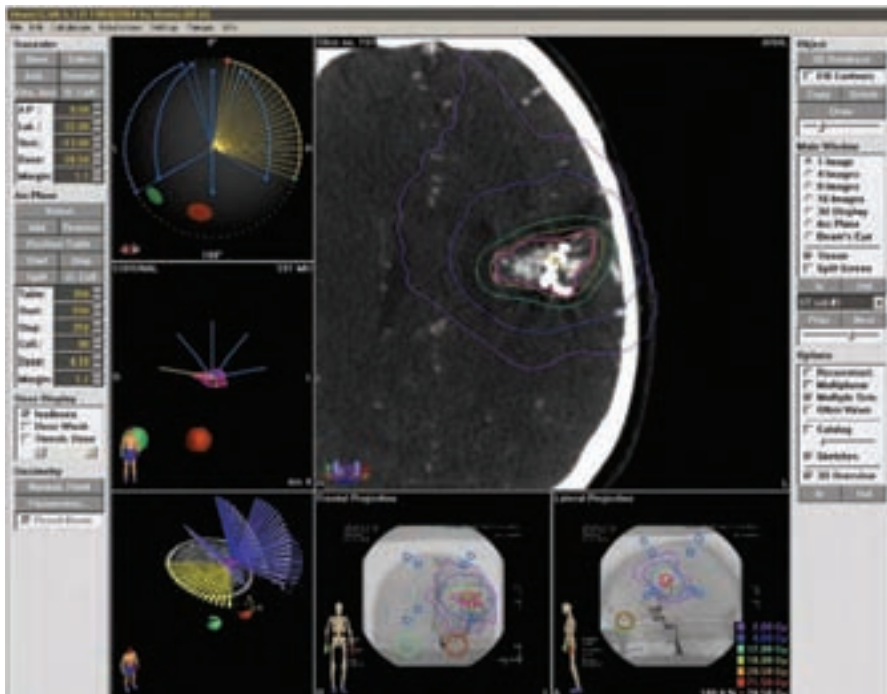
Stereotactic radiosurgery planning imaging. This patient presented with a haemorrhage sustaining motor and speech deficits. Following partial embolisation, referral for stereotactic radiosurgery was made. Conformal beam SRS was performed using CT angiography and formal invasive cerebral angiography to localise the lesion. Radiation was delivered using 5 arcs. Repeat angiography 2.5 years after treatment confirmed AVM obliteration. Pre-treatment planning should be undertaken between a neurovascular surgeon, a radiation oncologist and a neuroradiologist to optimise the treatment pathway.
